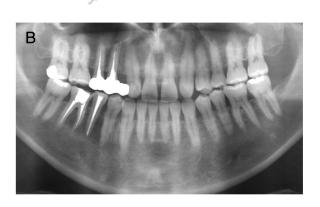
(*4*) Intraoral radiography of tooth #28–30. (*B*) Panoramic radiography showing radiolucency at teeth #29 and #30; the boundary of this lesion was unclear.
